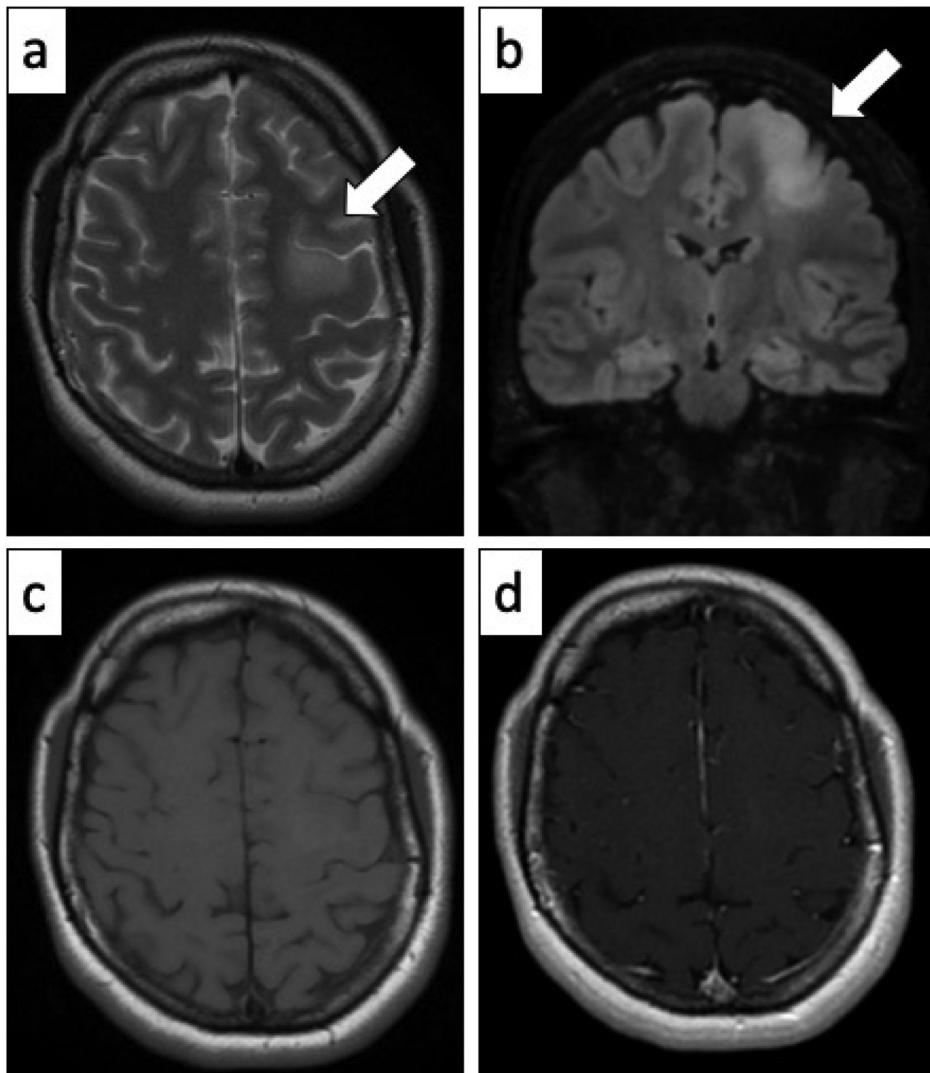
(a) Axial T2-weighted magnetic resonance (MR) image shows a slightly hyperintense mass located in the superior left frontal gyrus (arrow), mainly located at the level of white matter with extension into the adjacent cortex. On Coronal Fluid Attenuated Inversion Recovery (FLAIR) image (b) it appears hyperintense compared to the normal white matter without showing any sign of edema or mass effect on adjacent structures. On T1-weighted MR image (c) appears isointense to the normal brain, not visible at all. After intravenous injection of gadolinium based contrast media (d), it shows no enhancement.
